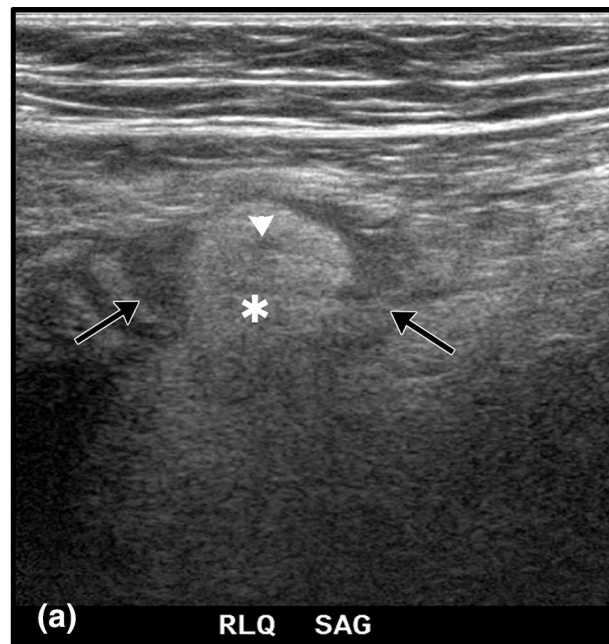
Epiploic appendagitis in a 18-year-old female with right lower quadrant (RLQ) pain. a Gray scale and b Color Doppler transverse images of the right lower quadrant demonstrate a focal area of echogenic fat (asterisk) with surrounding hypoechoic halo (black arrows), inseparable from the adjacent bowel. Central hypoechoic-ity represents venous congestion (arrow head in a and b). Patient had
